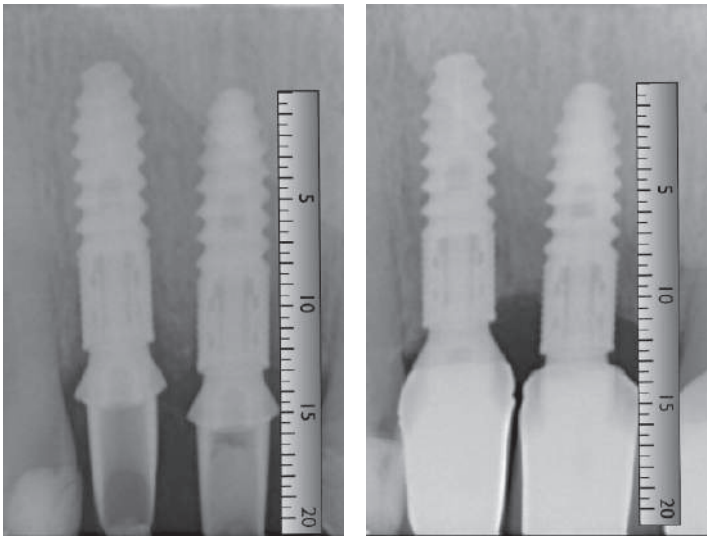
The calibration of ruler on the x-ray images
